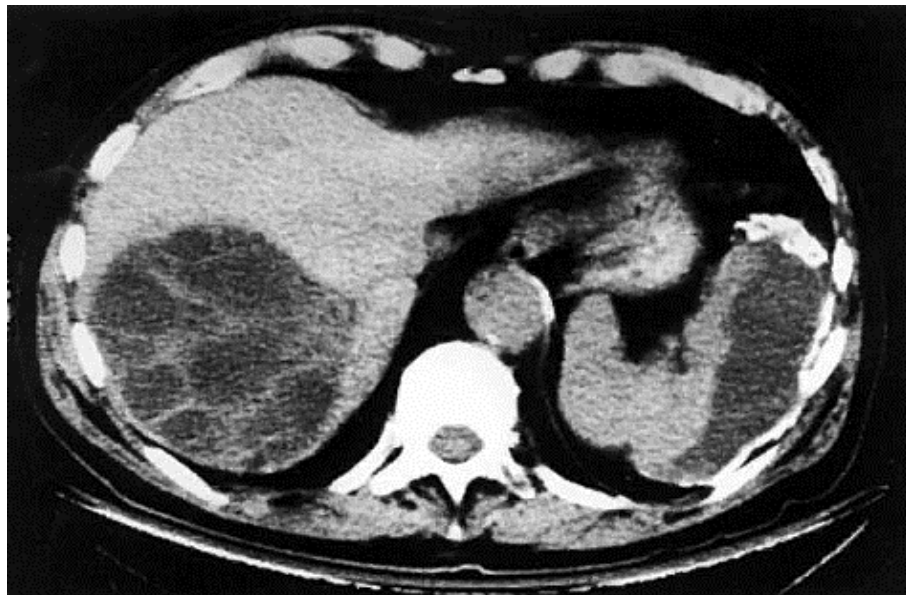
Abdominal CT scan showing a large primary Hydatid cyst (*Echinococcus granulosus*) in the right lobe of the liver. Note multiple internal septations indicating secondary (daughter) cyst formation.
